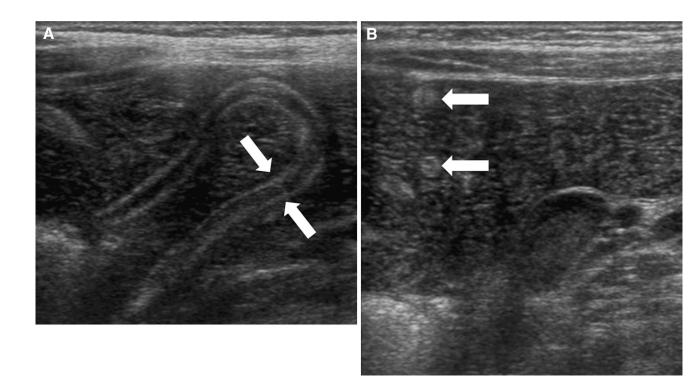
Ultrasound image of a 12-year-old boy from Pakistan presenting with abdominal pain (A) demonstrates two long parallel curvilinear echogenic structures within the small bowel separated by a hypoechoic region (*arrows*). Transverse
